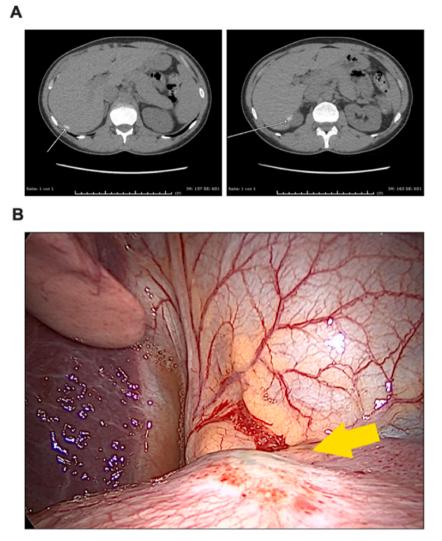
Perioperative findings. (A) CT thorax images showing suspected hyperdense pleural lesions. All scale bars are represented in the images. (B) Intraoperative finding of the later resected nodular blueish diaphragmatic pleura lesion (arrow). (1.5-column fitting image).
